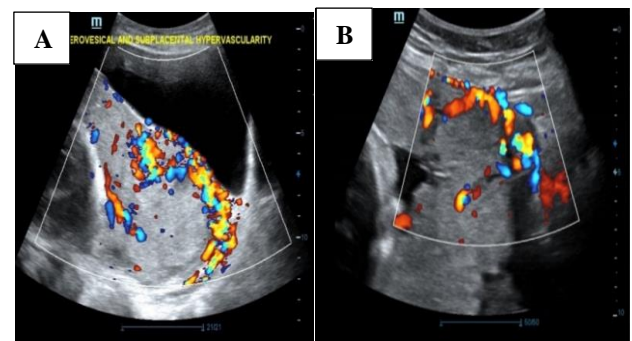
Colour doppler findings. A) Retroplacental uterovesical hypervascularity; B) Large placental lacunar feeding vessel.
